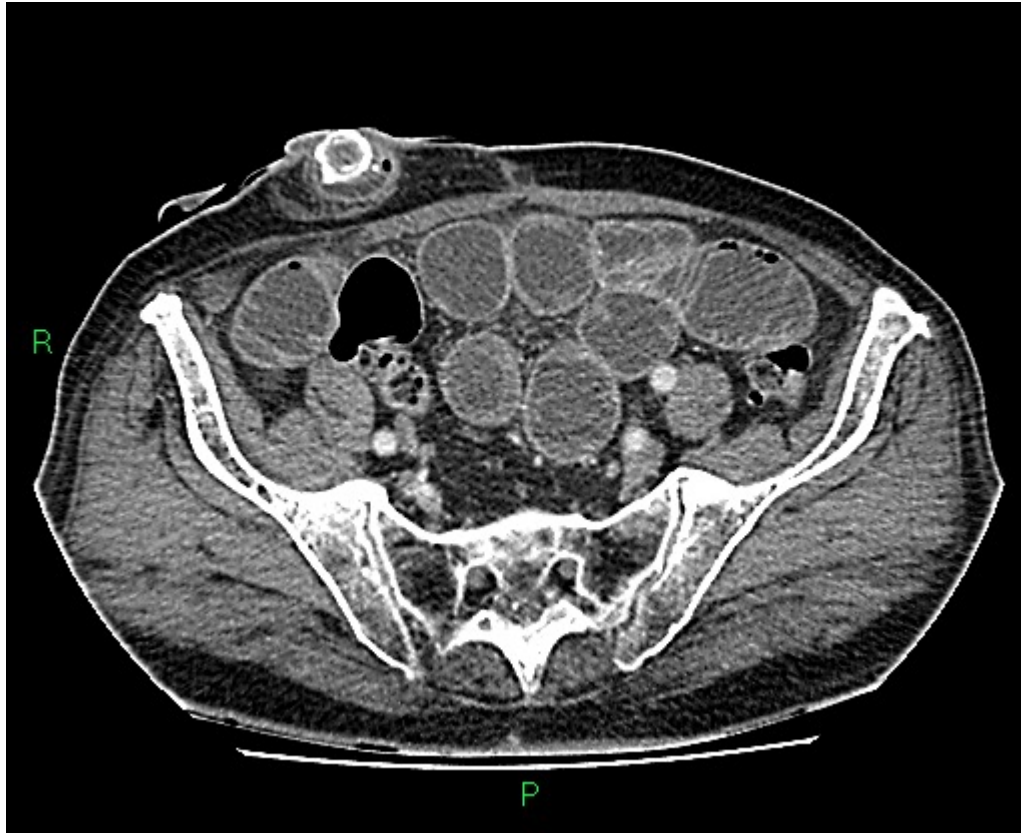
CT in axial plane showing multiple dilated loops of small bowel secondary to gallstone within ileostomy tract.
